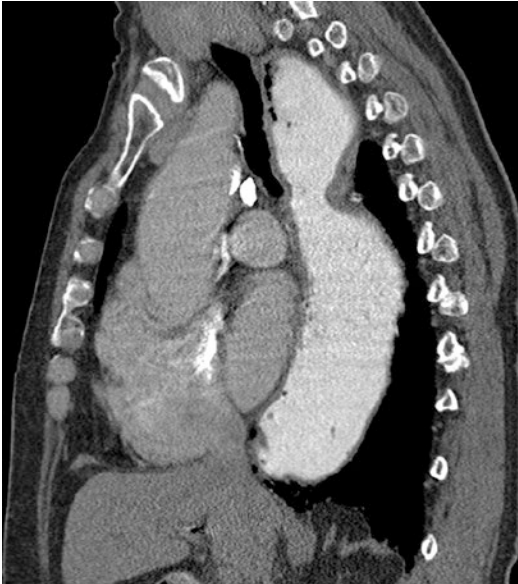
Sagittal CT with oral contrast of a 78-year-old female patient with Chagas disease of the esophagus. The image demonstrates as significantly dilated, contrast-filled esophagus
